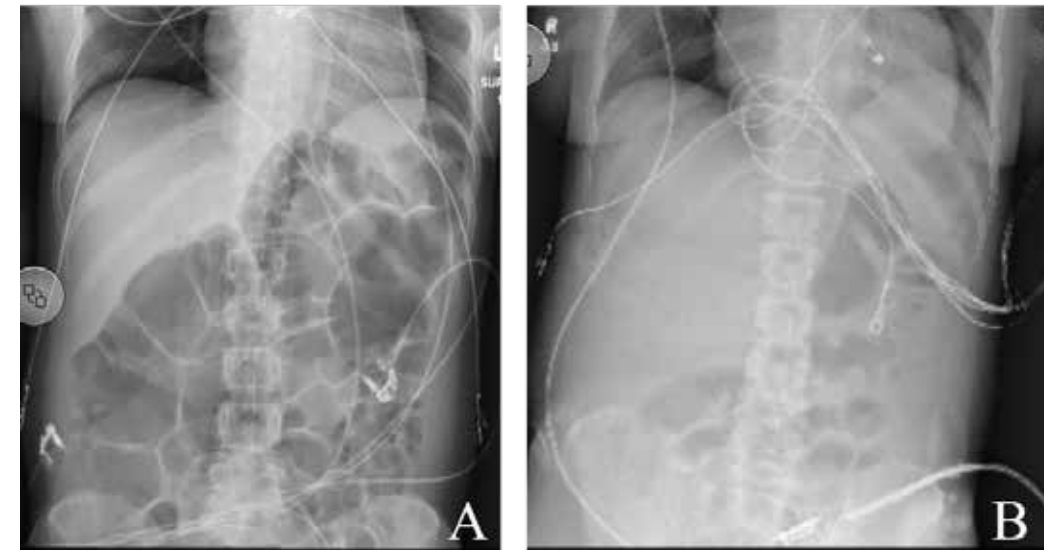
Case 1 Abdominal X-rays A) X-ray taken on the morning of the Impella 5.5 insertion B) X-ray taken on the morning of the left ventricular assist device placement.
